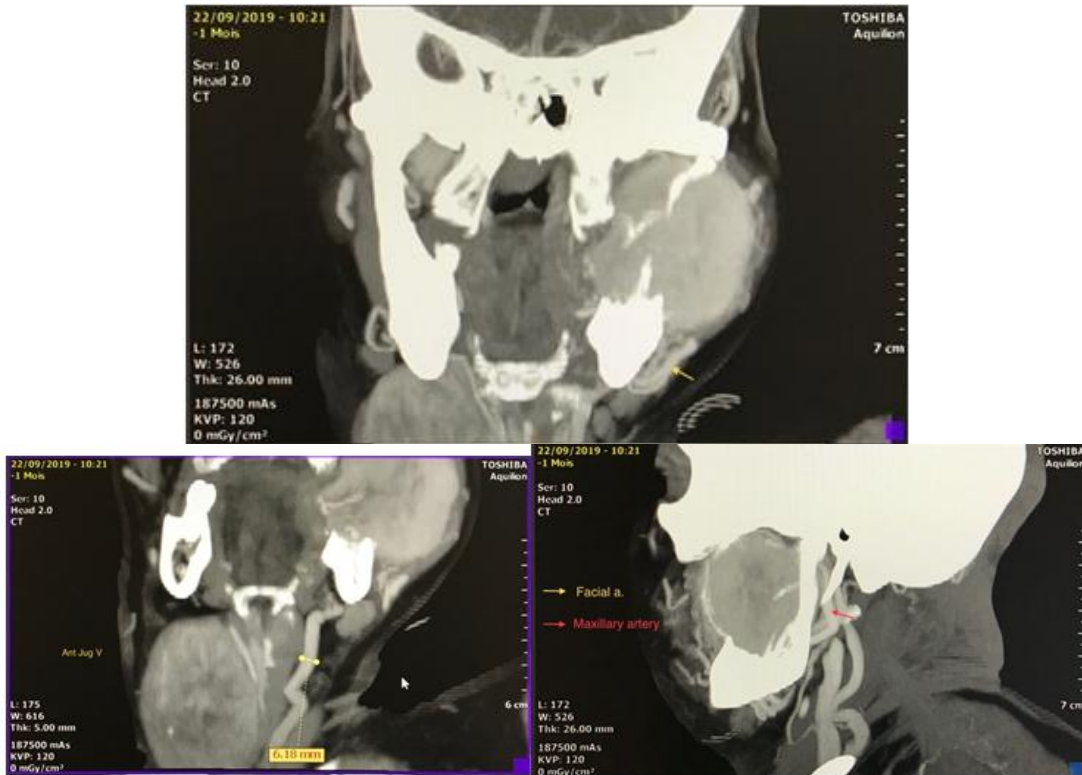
CT Angiogram showing facial artery and maxillary artery as feed vessels to the mandibular tumor, anterior jugular vein to be the principle drainage
